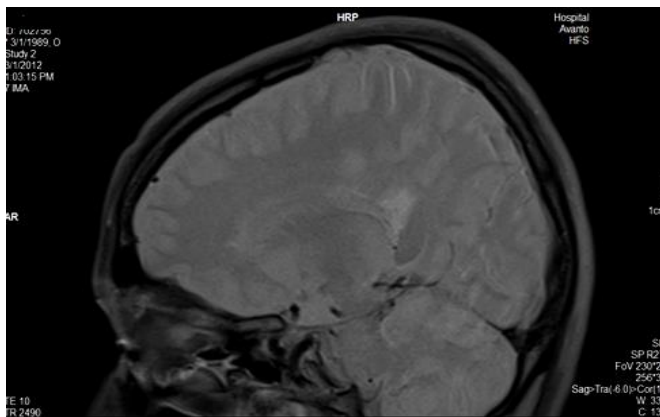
These images show the MS plaques in subcortical white matter area with three MRI pulse sequence: A is FLAIR, B is PDW-Fat sat and C is PDW-Water sat.
